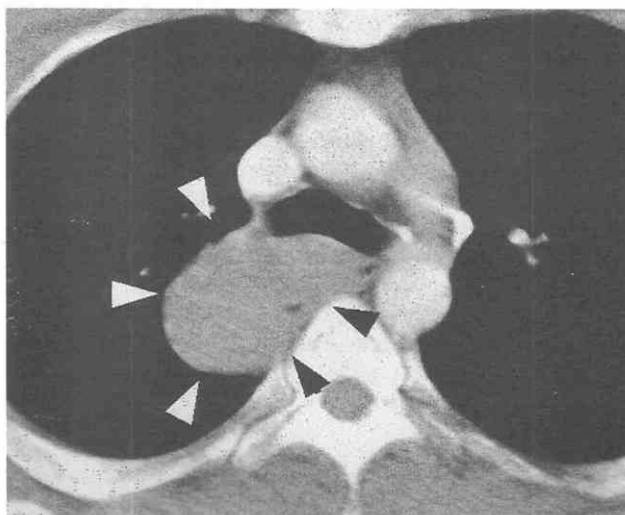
Leiomyoma of the esophagus. CT scan shows an eccentric mass (arrowheads) of the esophagus at the level of the carina. The lesion shows a smooth margin and homogeneous soft tissue attenuation.
